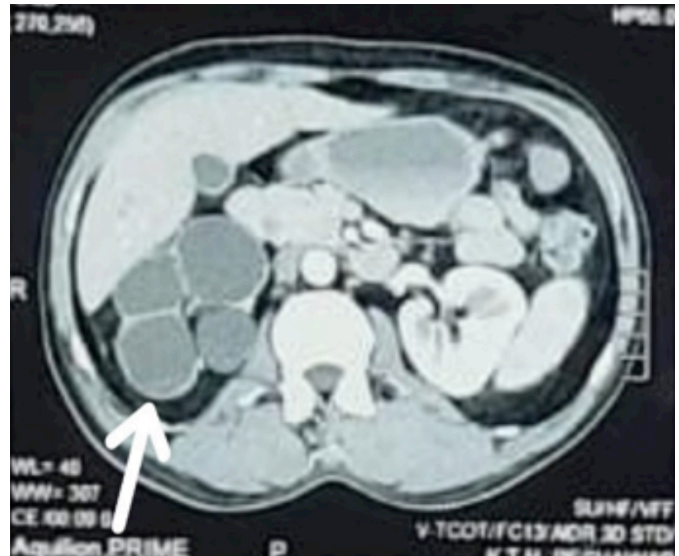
CT scan of abdomen and pelvis with oral and intravenous contrast. The arrow points towards the multiloculated, marginally enhancing collection in the right iliopsoas muscle bulging into the right iliac fossa.
